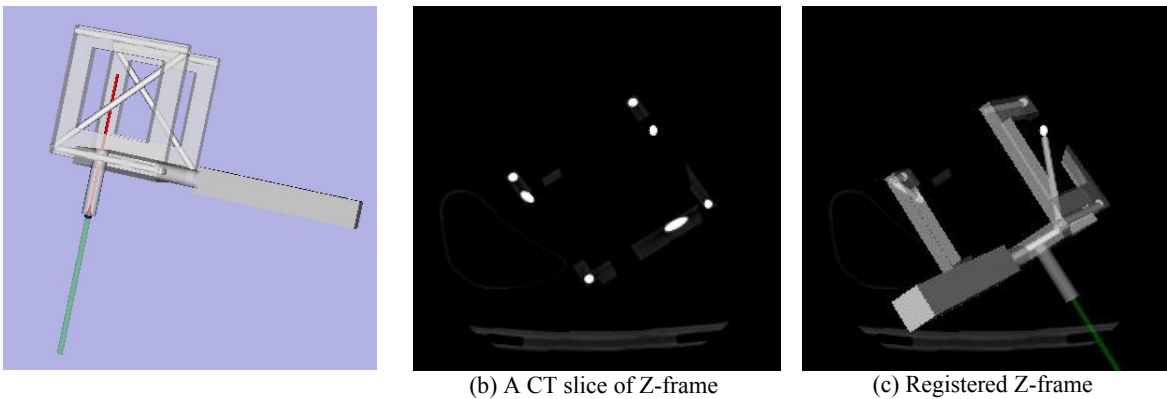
Registration of Z-frame to CT
